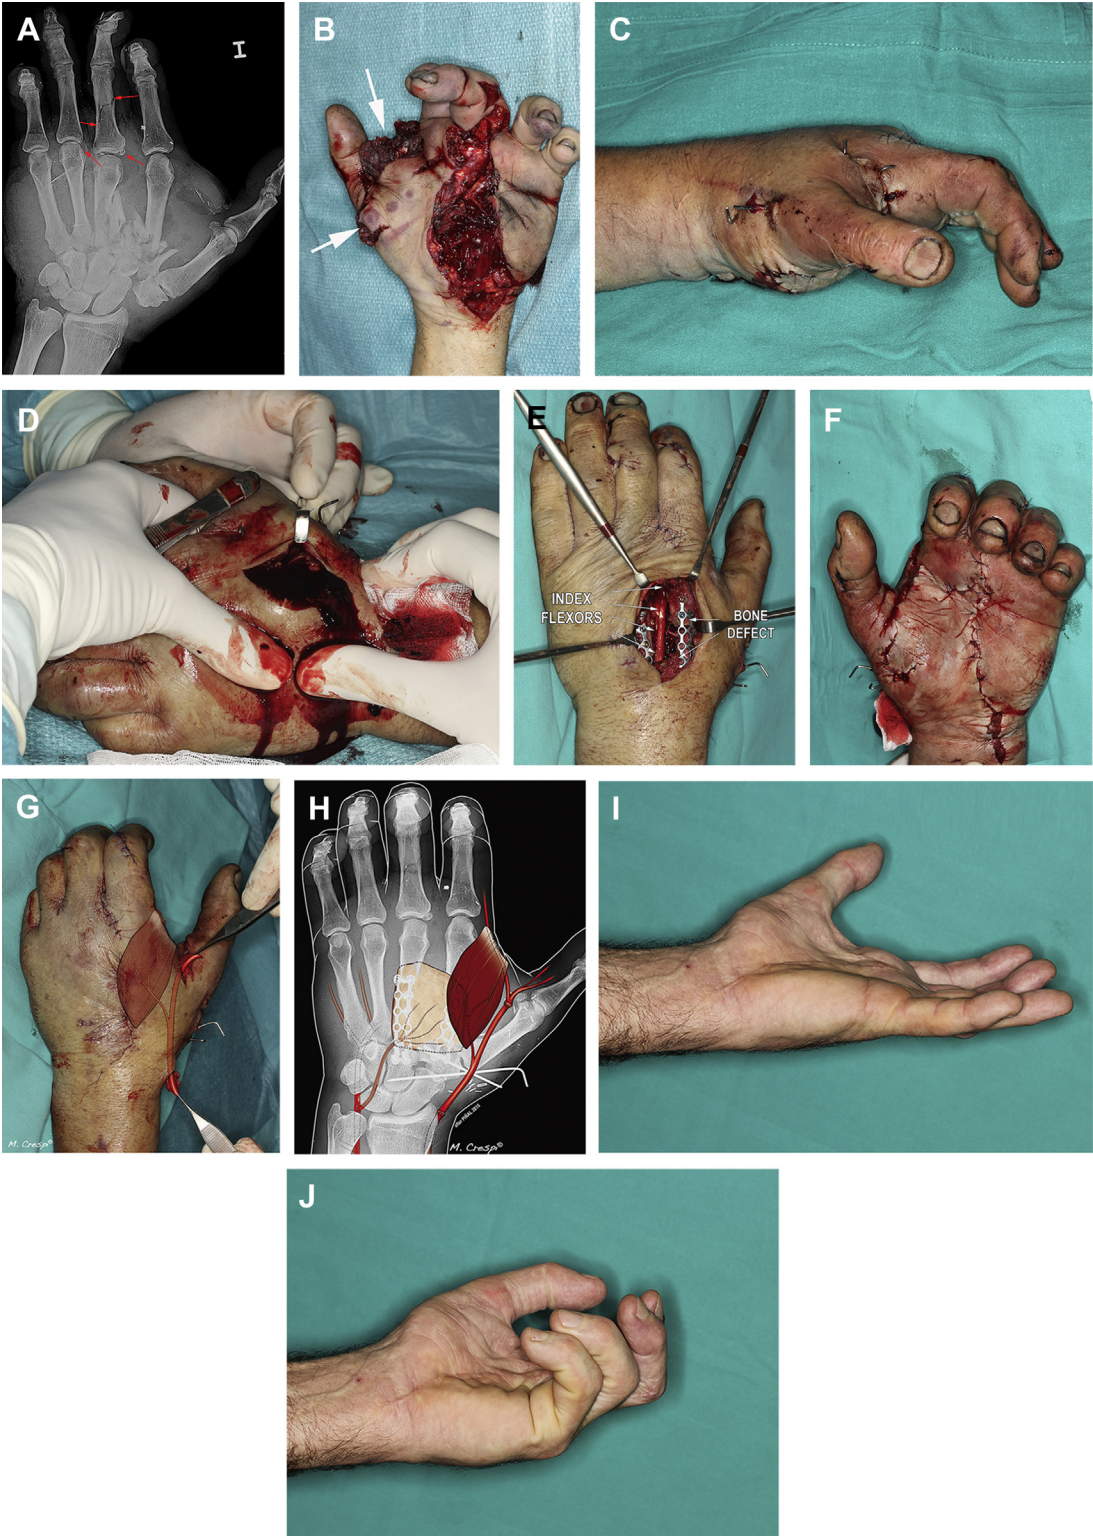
(A, B) Massive crush injury at the central portion of the hand. Debridement and primary stabilization were carried out as an emergency. Notice that the first web space and thenar musculature (*arrows*) suffered hydraulic extrusion. The radial side of the hand had marginal blood supply, with Doppler signals in the dorsum of the thumb only. (C, D) Three days after the injury, secondary to hematoma and edema, a massively swollen “balloon”
